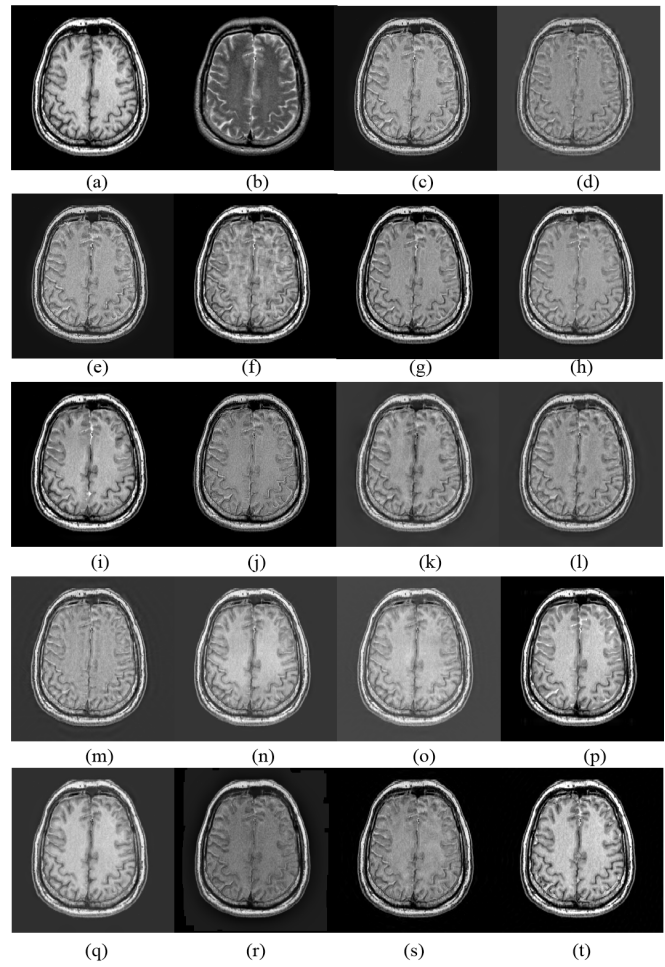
Experiments for S5. (a) CT. (b) MRI. (c) GP [52]. (d) DWT [52], [53]. (e) fsdP [52]. (f) GFS [54]. (g) CSR [55]. (h) ASR [56]. (i) GFF [57]. (j) MSVD [58]. (k) DTDWT [59]. (l) SWT [60], [61]. (m) CVT [62]. (n) DTCWT-SR [63]. (o) CVT-SR [63]. (p) LRSDL [64]. (q) PCLLE [65]. (r) MSGIF [66]. (s) DCHWT [67]. (t) Proposed.
